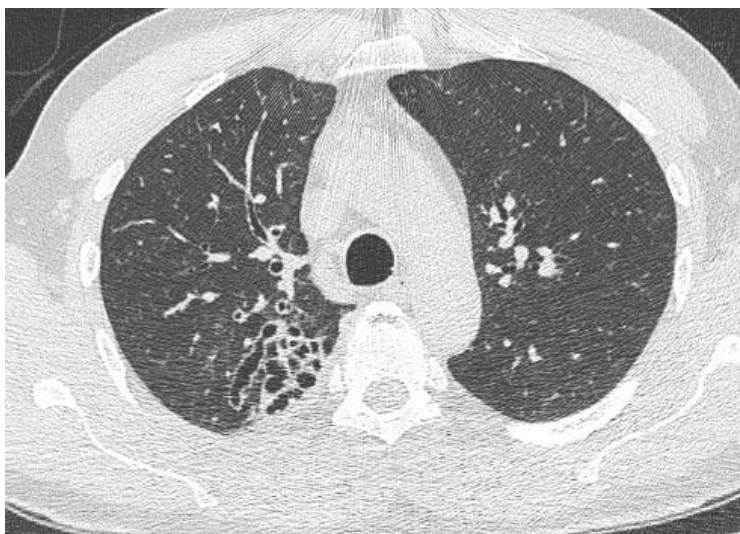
Axial thin-section chest CT image demonstrating localized cystic bronchiectasis in the right lung.
